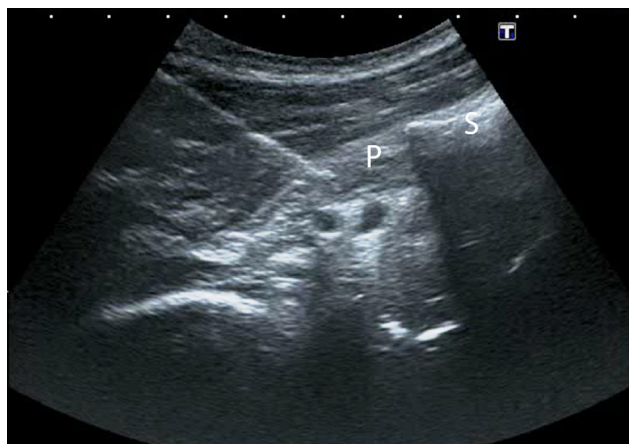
Sonographic cross-section taken during botulinum toxin (BT) injection into the piriformis muscle. P: piriformis muscle; S: sacrum.
